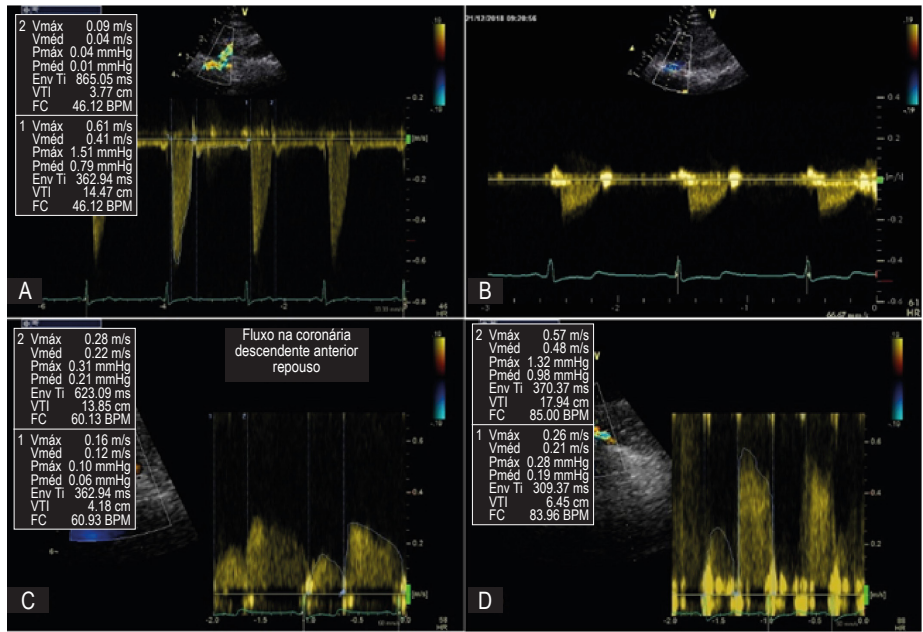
(A) Right internal thoracic artery (ITA) in situ shows a normal flow pattern with high systolic velocity and low diastolic velocity. (B) Left ITA anastomosed into the left anterior descending coronary artery (ADA) with only systolic flow and low flow velocity, which is compatible with the ITA occlusion. (C) ADA has a high diastolic flow velocity at rest. (D) Stress echocardiography revealed that diastolic flow velocity in the ADA doubles at 60% of the maximum predicted HR.
